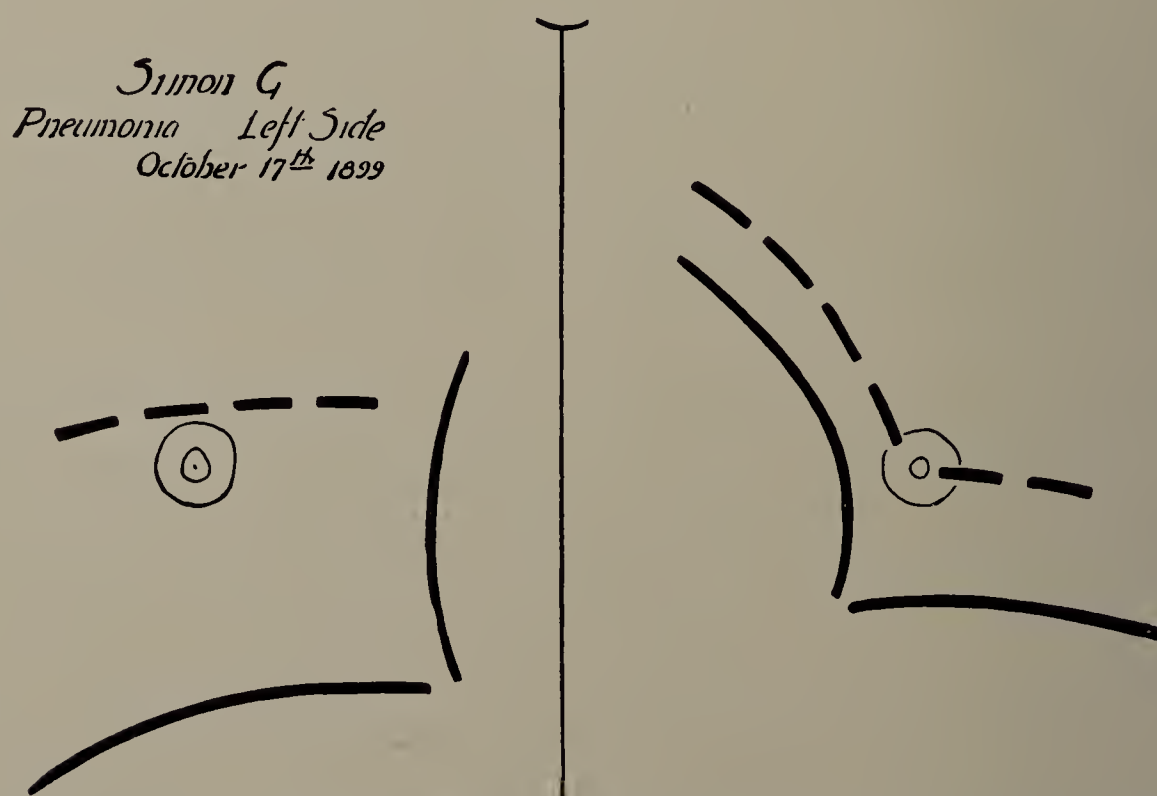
Simon G. October 17. Cut of third X-ray tracing. Both lungs nearly alike in brightness. Diaphragm on left side moves more than at last X-ray examination, but its movement is not yet normal. This abnormality may be due to pleuritic adhesions. (One-third life size.)
